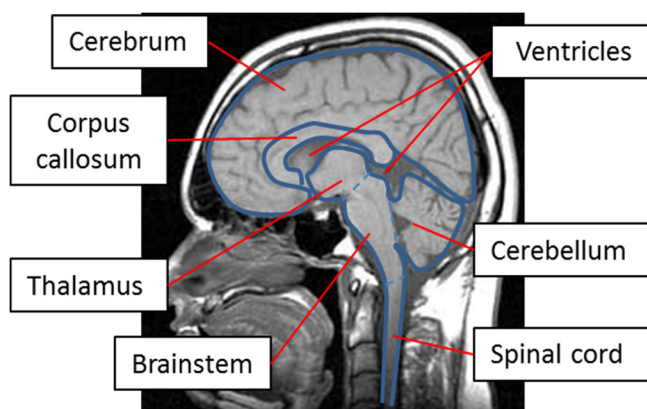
Sagittal plane view of a human brain MRI
